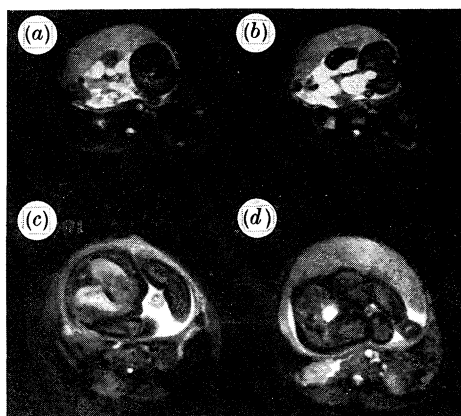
EPI MR images through the fetus *in utero* at 36 weeks gestation. (a) and (b) show a gastroschisis with the displaced fetal intestine within the amniotic fluid and a cleft in the anterior abdominal wall. (c) Section through the normal thorax showing the heart and fluid filled fetal lungs, (d) section through the normal pelvis showing the fetal bladder and lower limbs.
